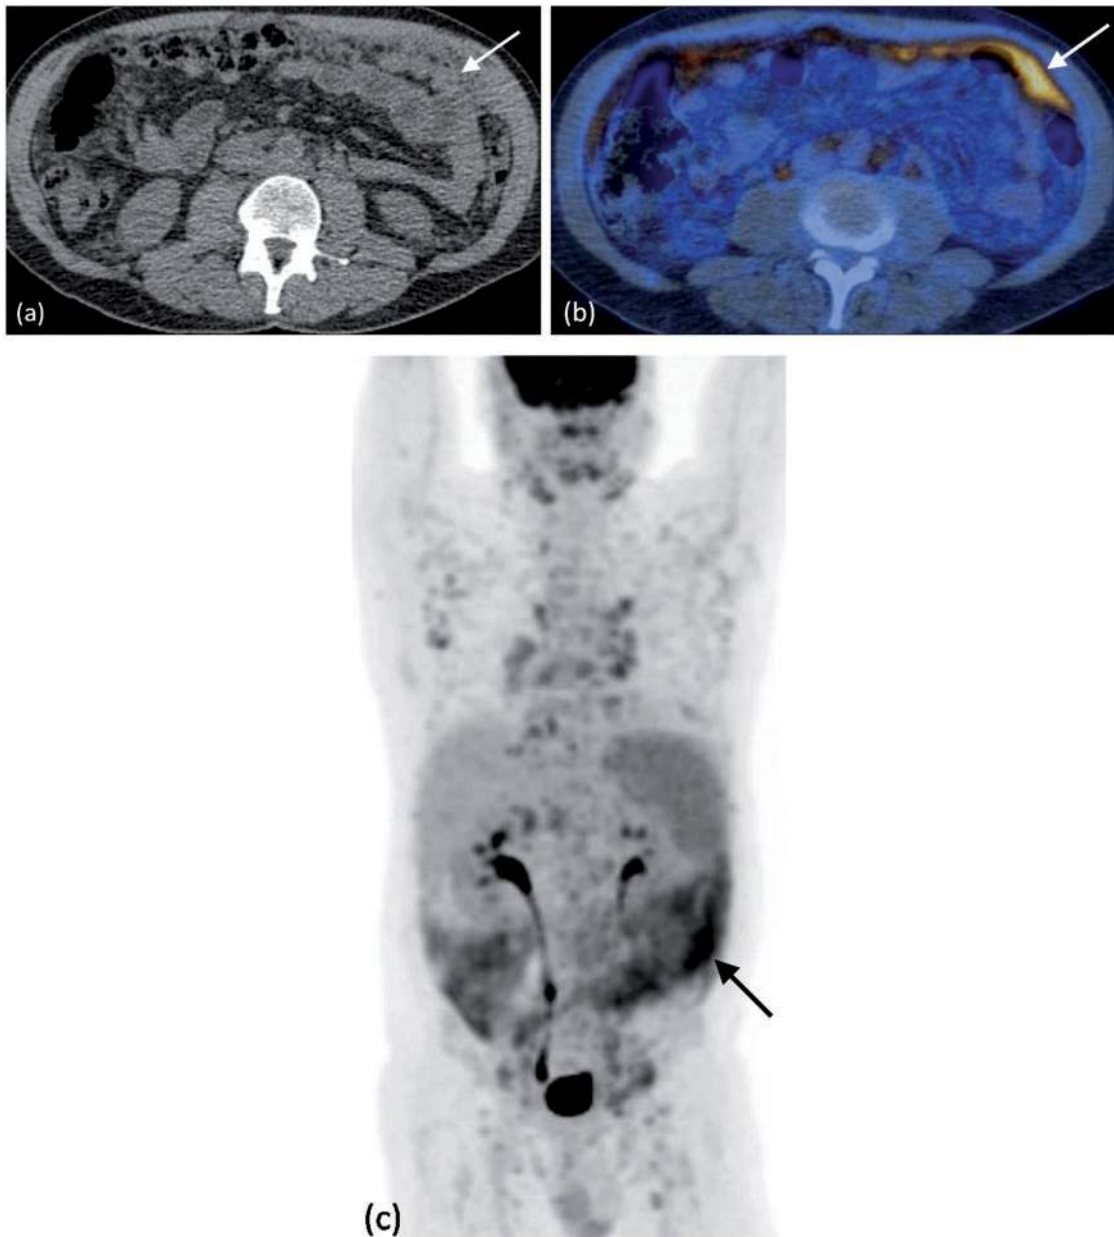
Peritoneal lymphoma. FDG PET/CT demonstrates diffuse deposits within the greater omentum (arrows) on (a) unenhanced CT. (b) Axial fused PET/CT and (c) coronal PET images show multiple areas of increased uptake within these and other greater omental deposits, including several retroperitoneal nodes (arrows).
